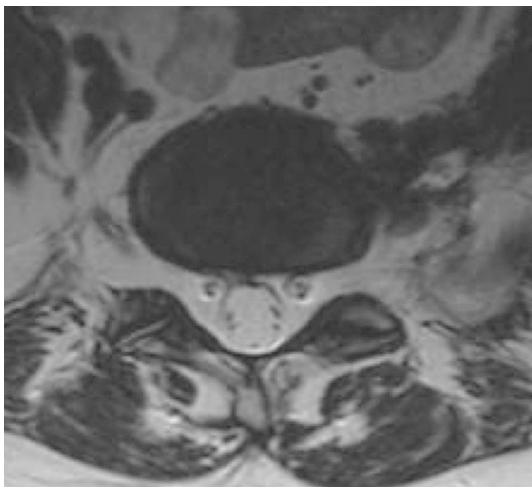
1-year MRI showing a completely free left L5 nerve root
